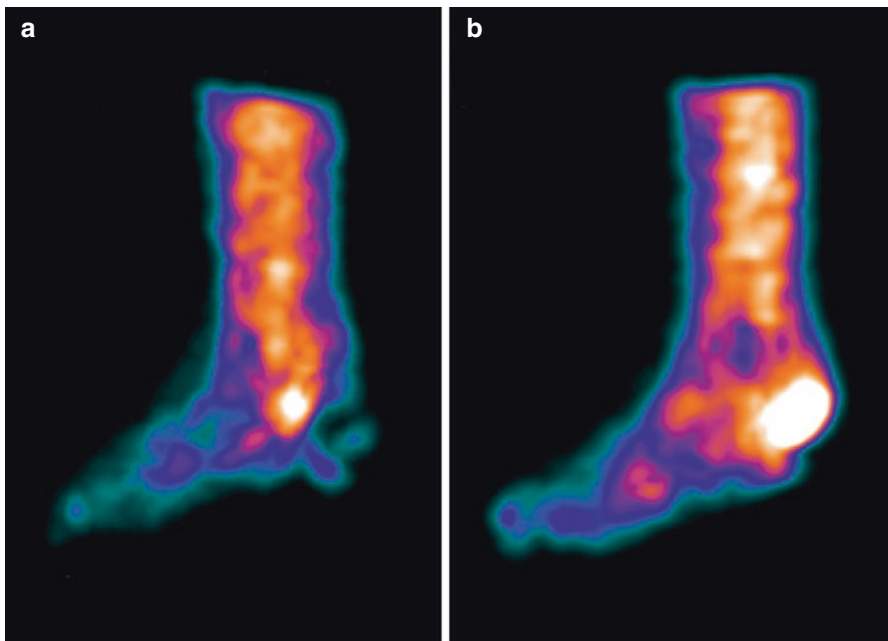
Sagittal view of ^{99m}Tc -tetrofosmin SPECT imaging in a patient with nonhealing heel ulcer before (a) and after (b) lower extremity revascularization and wound debridement shows increased tracer uptake in the heel and distal foot
